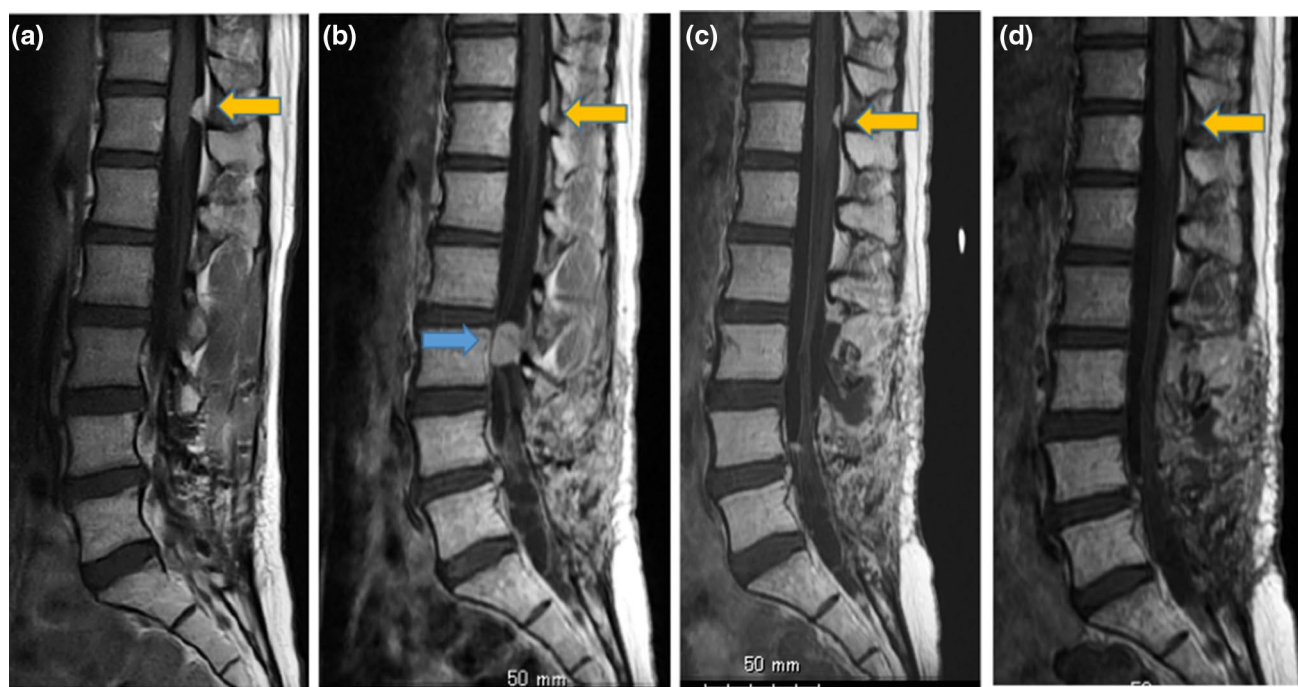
a 4 years after the initial surgery (when she was 30 years old), the follow-up MRI showed a new tumor located on the inner surface of the dorsal dura at T11/12. It was diagnosed as a disseminated metastatic tumor via CSF flow, and local radiotherapy was performed, but the tumor size did not change after radiotherapy. b 6 years after the initial surgery (when she was 32 years old), a new tumor re-occurred at the L3 level. c Gross total resection was achieved without
